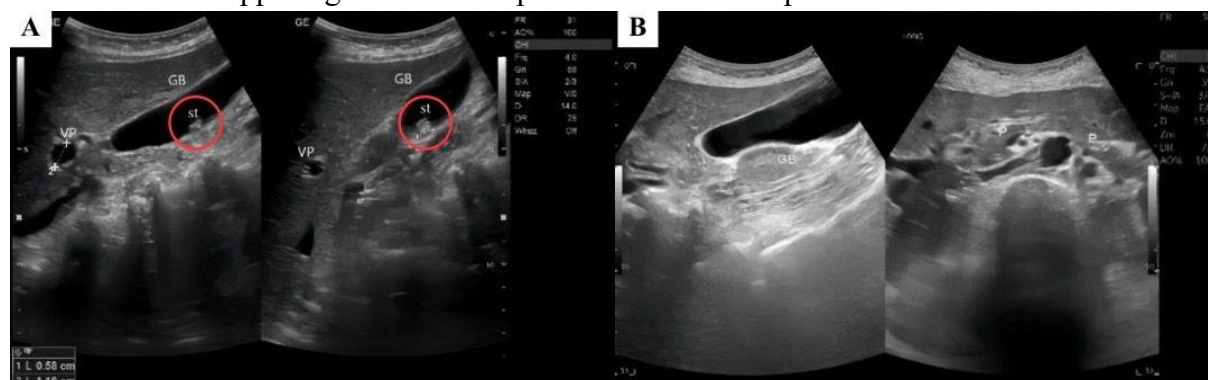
Comparison of ultrasound results before and after UDCA therapy.
